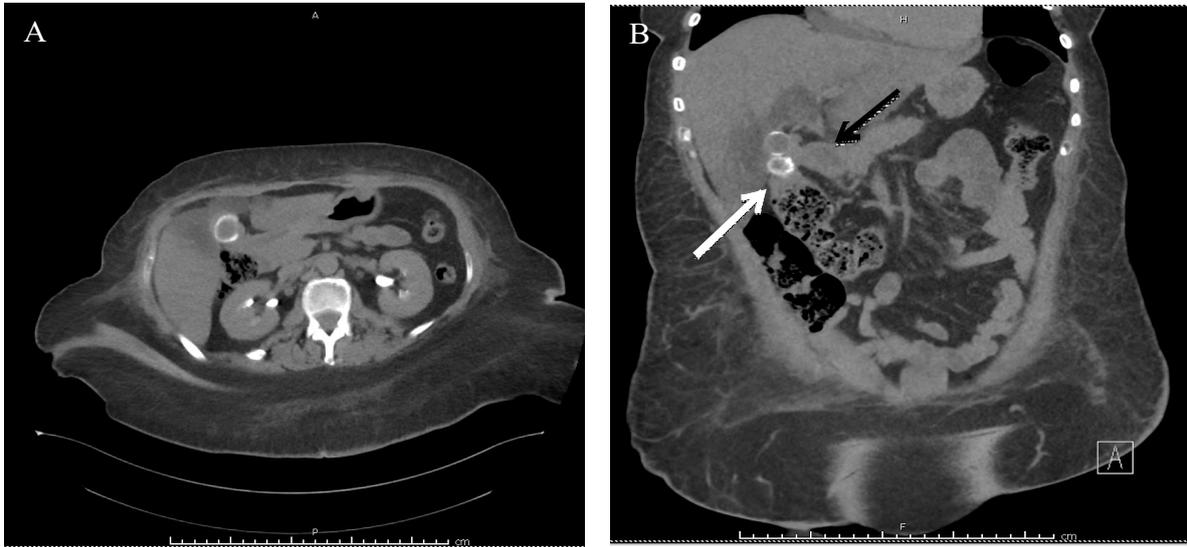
Abdominal CT with contrast demonstrating the presence of cholelithiasis. (A) The proximity of the duodenum and gallbladder can be appreciated by the hyperintense structure of the G-J tube. (B) The black arrow indicates the presence of pneumobilia superior to the gallstone.
